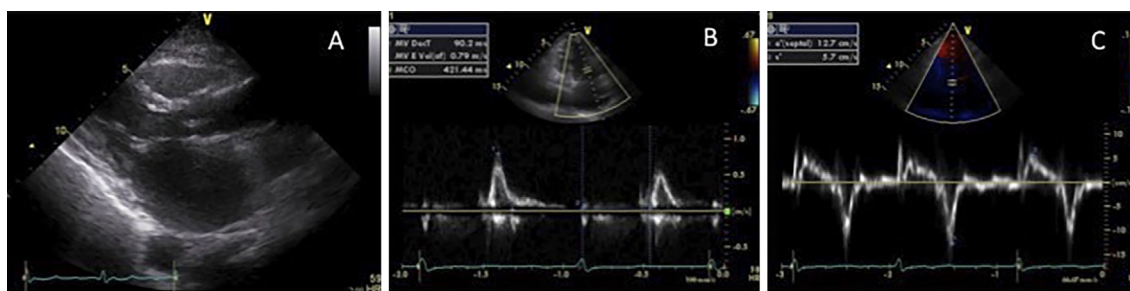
(A) Echocardiography showing left atrial enlargement and thickening of the posterior pericardium. (B) A mitral inflow Doppler recording demonstrating shortening of the deceleration time of the E wave (90.2 ms). (C) A medial mitral annular tissue Doppler recording (apical window) showing increased early relaxation velocity (e') (12.7 cm/s).
